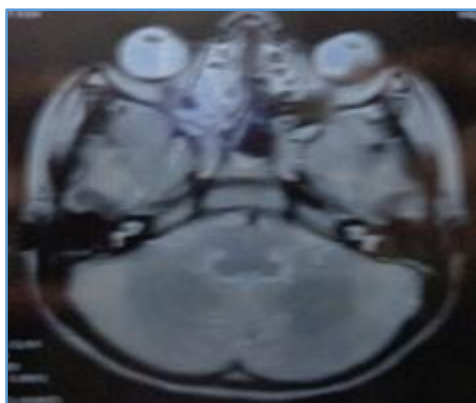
T2 MRI Image Showing Hypointense Lesion
